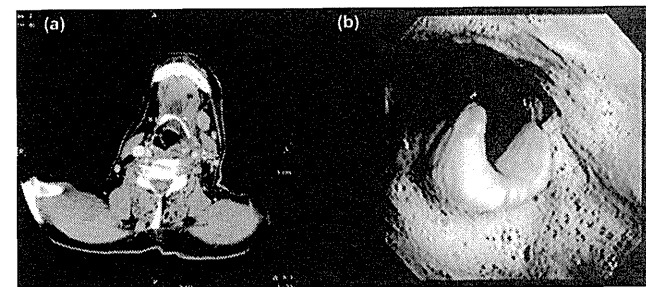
(a) CT scan at the supraglottic level revealed soft tissue thickening and enhancement of the left epiglottic folds and pyriform sinuses (green arrow). (b) Laryngoscope revealed that glottic, laryngeal, and subglottic soft tissues were inflamed.
